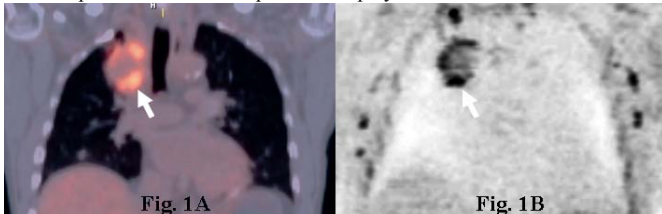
69-year old Stage IIIA NSCLC patients before chemoradiotherapy. PET/CT (Fig. 1A) and DWI (Fig. 1B) demonstrated high uptake of FDG and high signal intensity of tumor, especially in the periphery. SUV_{max} and ADC were assessed as 4.5 and 2.0×10⁻³mm²/sec. This case is PR case on RECIST criteria, and determined as false-negative on PET/CT and true-positive case on DWI.
